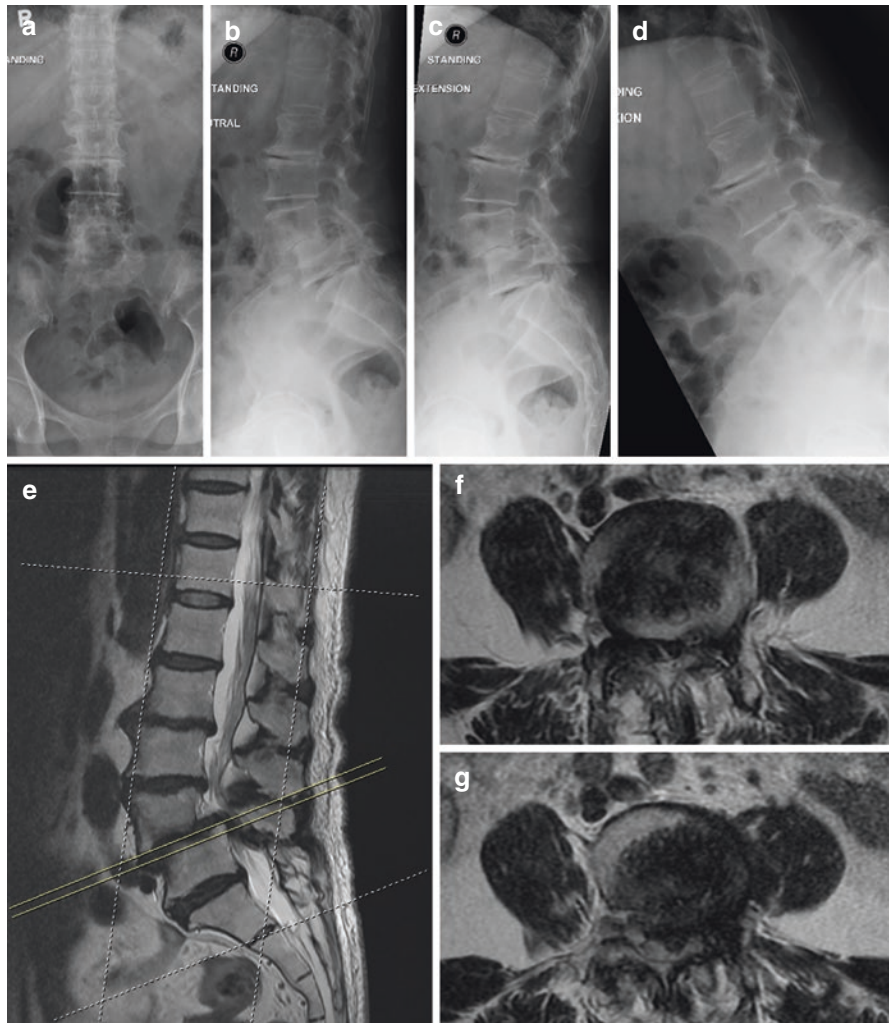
(a and b) Standing anteroposterior and lateral radiographs showing degenerative changes such as reduced intervertebral disc height and osteophytes. (c and d) Standing extension and flexion radiographs demonstrating no significant instability although there was L4/5 grade II spondylolisthesis. (e–g) T2-weighted sagittal and axial MRI showing the L4/5 spinal stenosis. The patient presented with spinal claudication without symptoms at rest. L4/5 decompression without fusion gave good symptomatic relief with improved walking tolerance (e–g)
